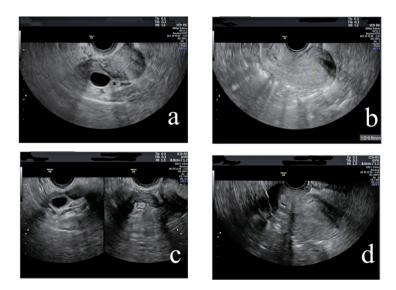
Ultrasound image findings at the time of the egg retrieval decision and on the day of egg retrieval Fig. 3a: Follicle of the right ovary (20×16 mm) on the egg retrieval decision.
